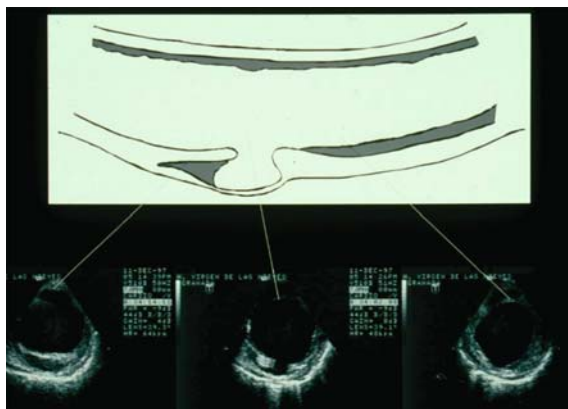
Transesophageal echocardiographic scans of a patient with aortic dissection secondary to a penetrating aortic ulcer. The true lumen is larger than the false lumen. Other signs of aortic atherosclerosis may also be seen
